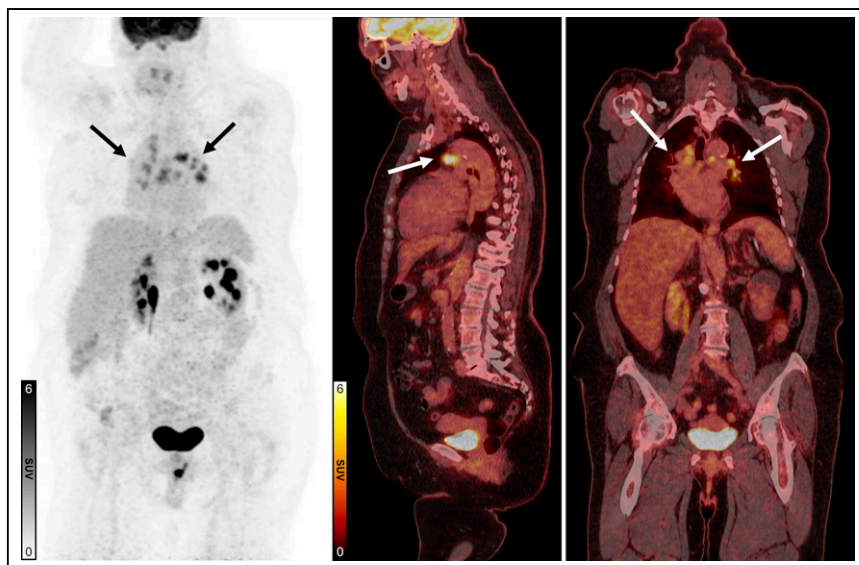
Scan 1 ^{18}F -FDG maximum-intensity projection (left), fused ^{18}F -FDG PET/CT sagittal (middle), and fused ^{18}F -FDG PET/CT coronal (right) views. Images show diffuse hypermetabolic uptake (arrows) in mediastinal and hilar lymphadenopathy biopsy-proven noncaseating granulomatous disease. ^{18}F -FDG PET/CT scan 1 is negative for cardiac sarcoidosis but positive for extracardiac sarcoidosis.
